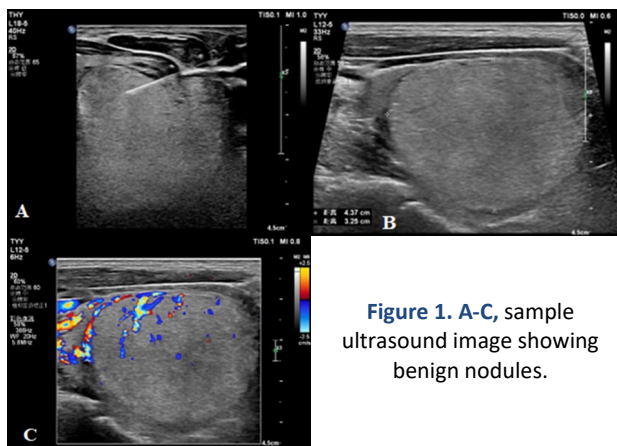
A-C, sample ultrasound image showing benign nodules.
